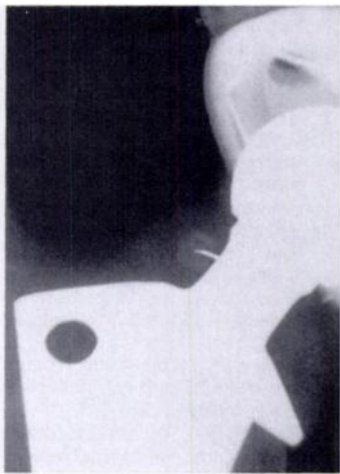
Spot radiograph of a 63-year-old patient who had undergone total hip arthroplasty. Aspiration was performed to rule out infection. Radiograph shows that the needle is positioned correctly, superolateral to the neck of the femoral component.
